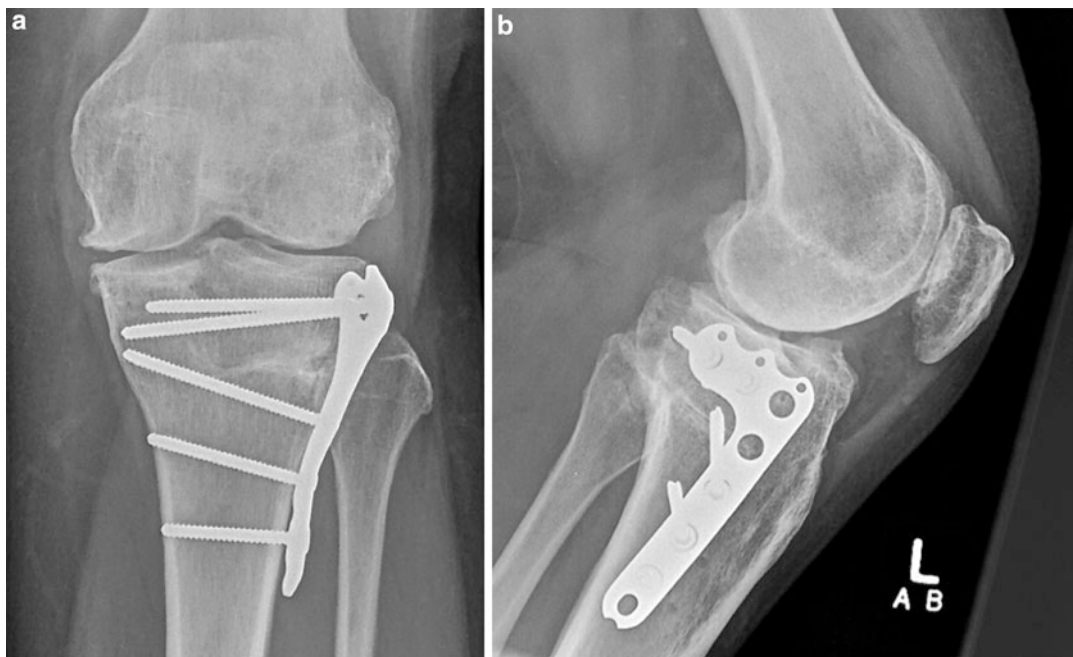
AP (a) and lateral (b) radiographs 4 years postoperative
